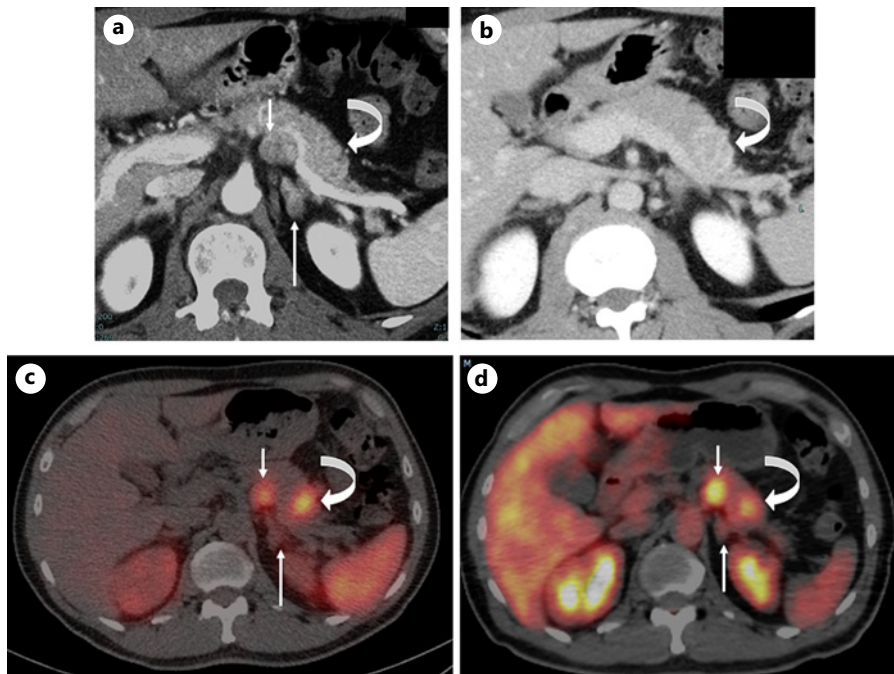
CT, SRS with SPECT/CT, and FDG-PET/CT findings of NEN tumor metastasis in primary pancreatic tail and #11p and #11d lymph nodes. a, b Contrast-enhanced CT showed a persistently enhanced mass measuring 20 × 25 mm in the pancreas tail (curved arrow), a significantly enlarged #11p node measuring 18 × 22 mm (short arrow), and vague findings in the #11d node measuring 8 × 10 mm (long arrow). c SRS with SPECT/CT showed abnormal uptake in the primary tail tumor (curved arrow) and #11p node (short arrow), whereas there was no abnormal uptake in #11d node (long arrow). d FDG-PET/CT showed mild FDG uptake with a maximum standardized uptake value (SUVmax) of 2.89 in the primary tail tumor (curved arrow) and mild uptake with an SUVmax of 3.42 in the #11p node (short arrow), whereas no uptake was seen in the #11d node (long arrow).
